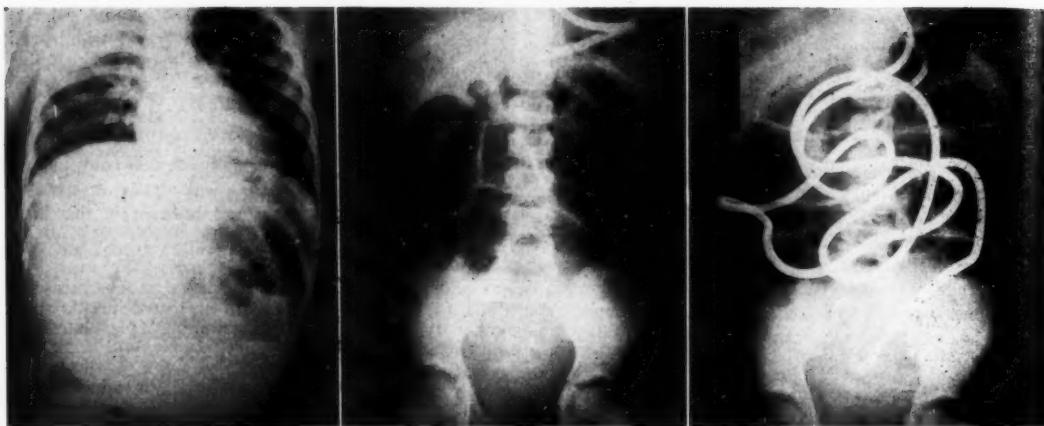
X-ray of chest and abdomen taken on entry to hospital, showing increased density over the right upper lung field and marked small bowel distention with fluid levels.
